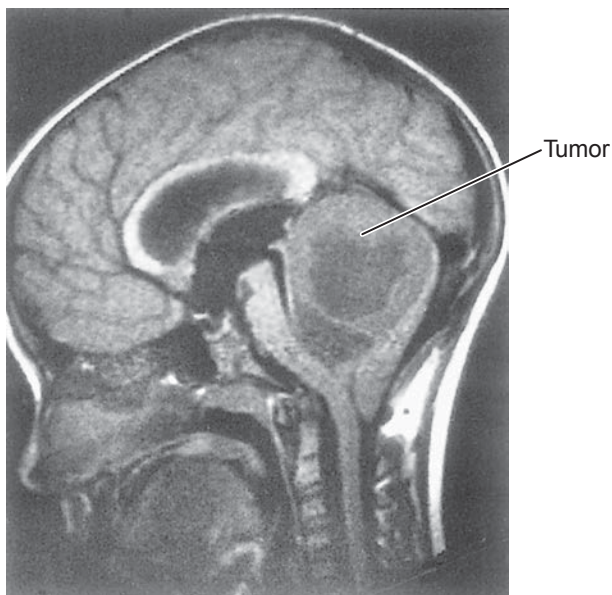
Brain tumor. MRI shows a large tumor that arises from the cerebellum and pushes the brainstem forward.
